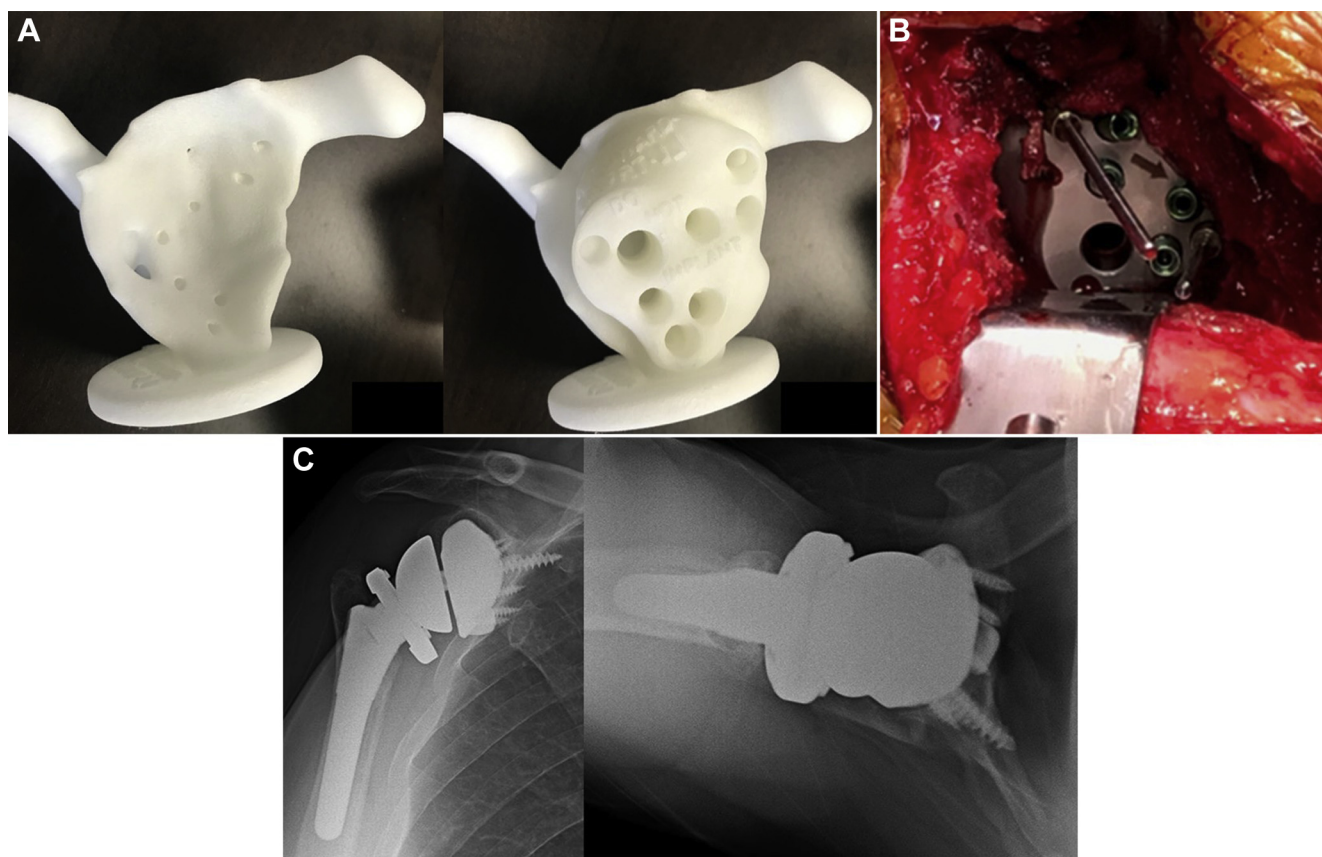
(A) Sterilizable polyamide models of the scapular bone and implant are used intraoperatively to guide exposure and ensure proper seating of the final implant. (B) Final Comprehensive Vault Reconstruction System (VRS) implant in situ with 2 drill bits inserted in predetermined peripheral holes for provisional fixation prior to central screw placement. (C) Postoperative anteroposterior and axillary radiographs of patient 2 at 27 months' follow-up. No change in implant position or evidence of loosening was observed after sequential review of all postoperative radiographs.
